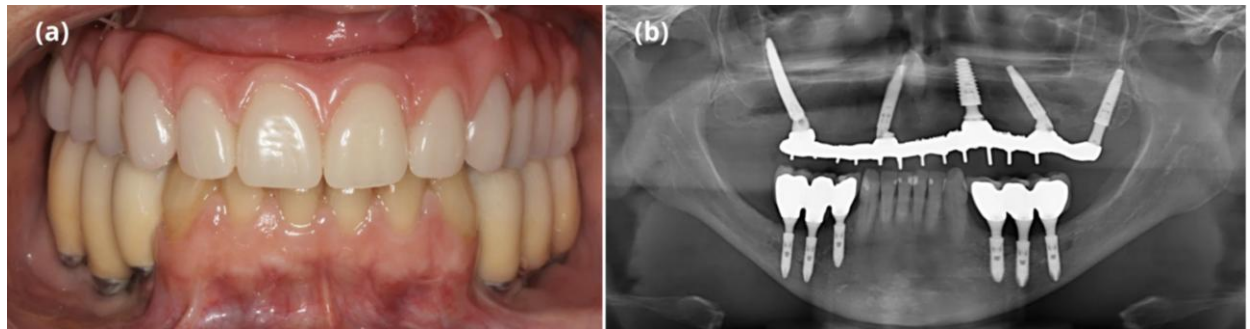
Placement of the final prosthesis. Frontal view (a) and panoramic radiograph (b).
